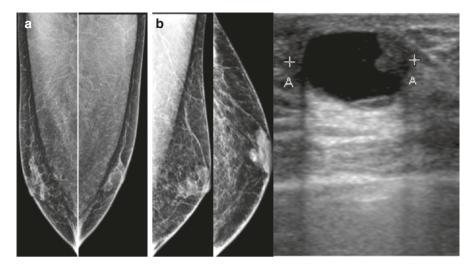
(a) Structure compatible with retropapillary fibroglandular tissue. (b) Lobular nodular retropapillary image and complementation with ultrasound, evidencing papillary growth near the wall. (b) Notice the nodular lobular retropapillary image and complementation with ultrasound evidencing papillary growth near the wall (*PA* papillary carcinoma)
